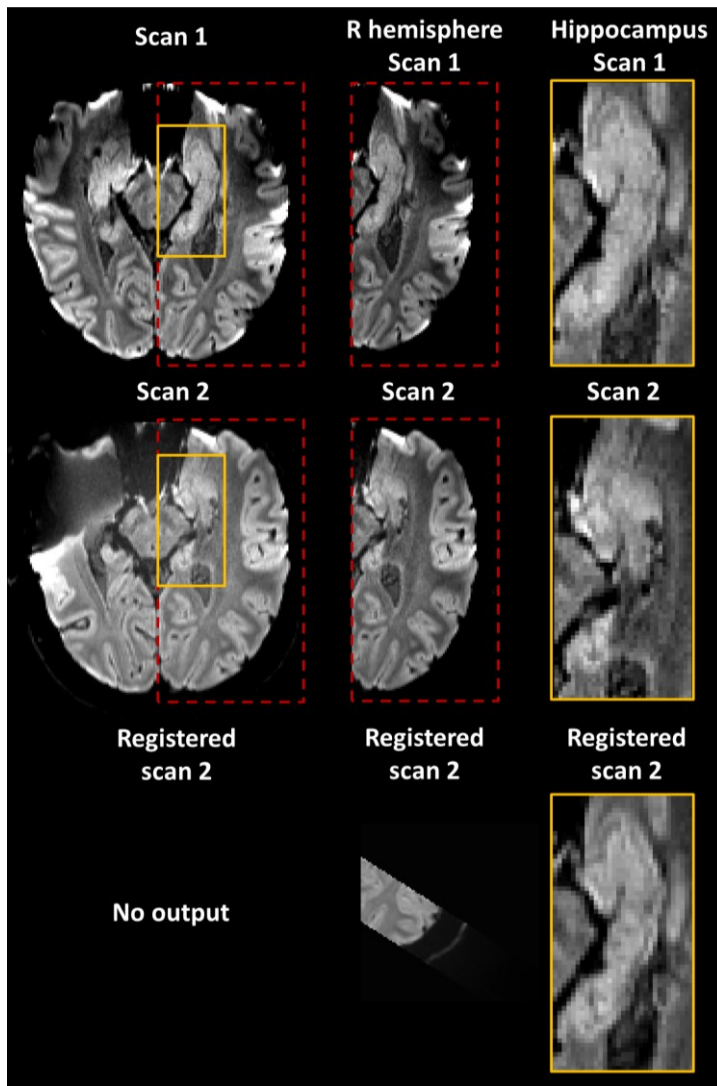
Mean DWI slices from a TLE patient that underwent surgical resection of the anterior temporal lobe after scan 1. Left column: co-registration of the two scans failed to produce any results. Middle column: co-registration of the extracted left hemisphere (red dotted box) did not achieve spatial correspondence between the two scans. Right column: co-registration of the extracted hippocampus (yellow boxes) resulted in excellent correspondence between the scans.
